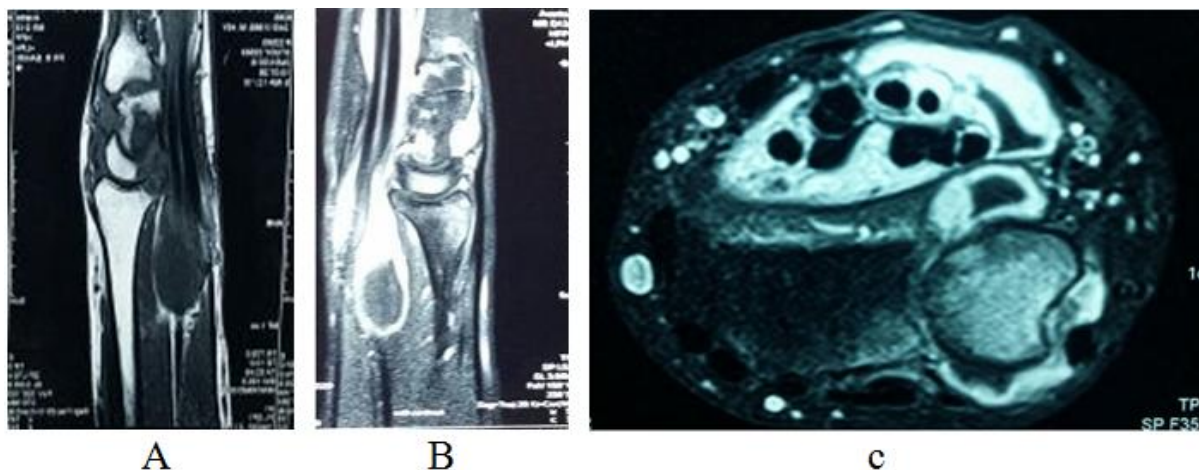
Magnetic resonance images. (A) T1-Weighted sagittal (B) T1-Weighted sagittal postcontrast. (c) T1-Weighted axial images demonstrating carpal mass compressing median nerve
